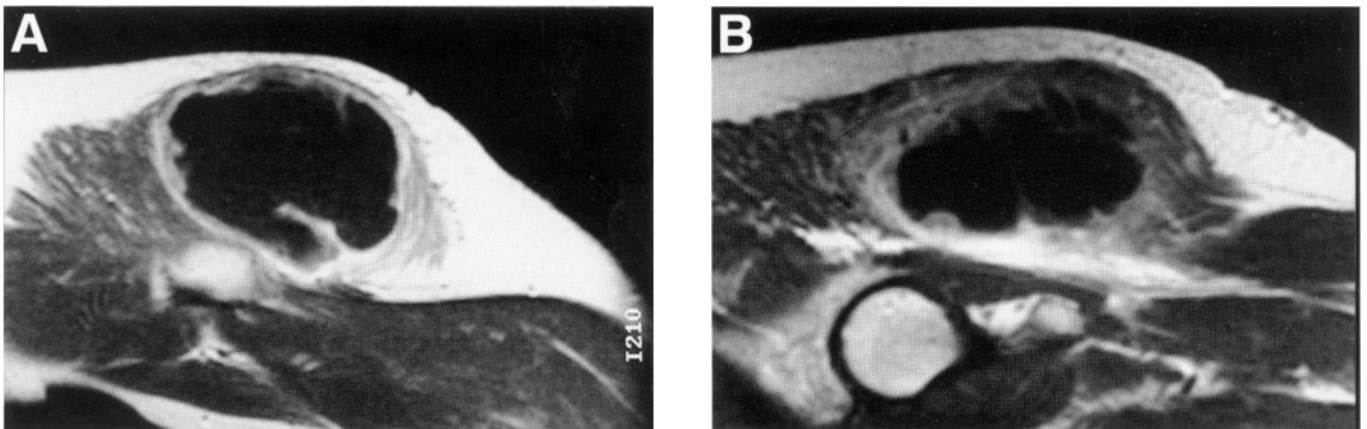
(A and B) Coronal MRI views. T1 weighted image of a large buttock sarcoma. Note there is no extension distally or to the adjacent hip joint.
